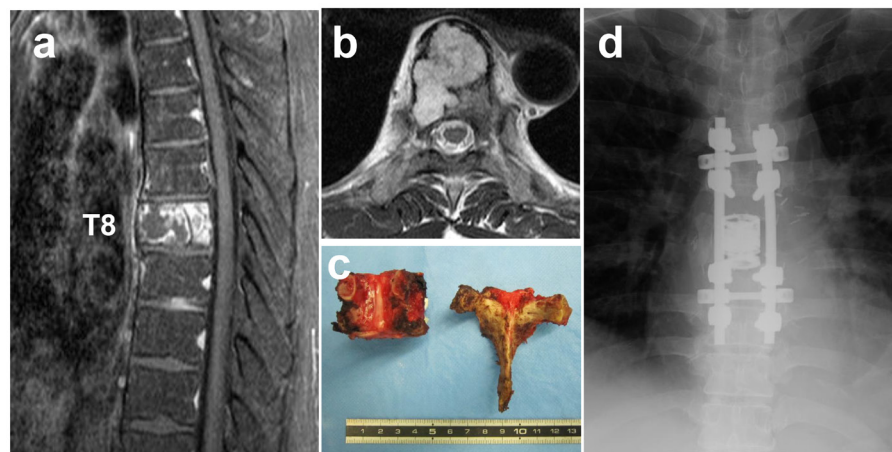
Representative case of vertebrectomy. (a) A sagittal T2-weighted fat-suppressed MRI image of a 40-year-old male with T8 chondrosarcoma (Grade I). (b) Axial T2-weighted MRI image. (c) Macroscopic view of resected vertebra. (d) Postoperative X-ray of the thoracic spine (AP view).
